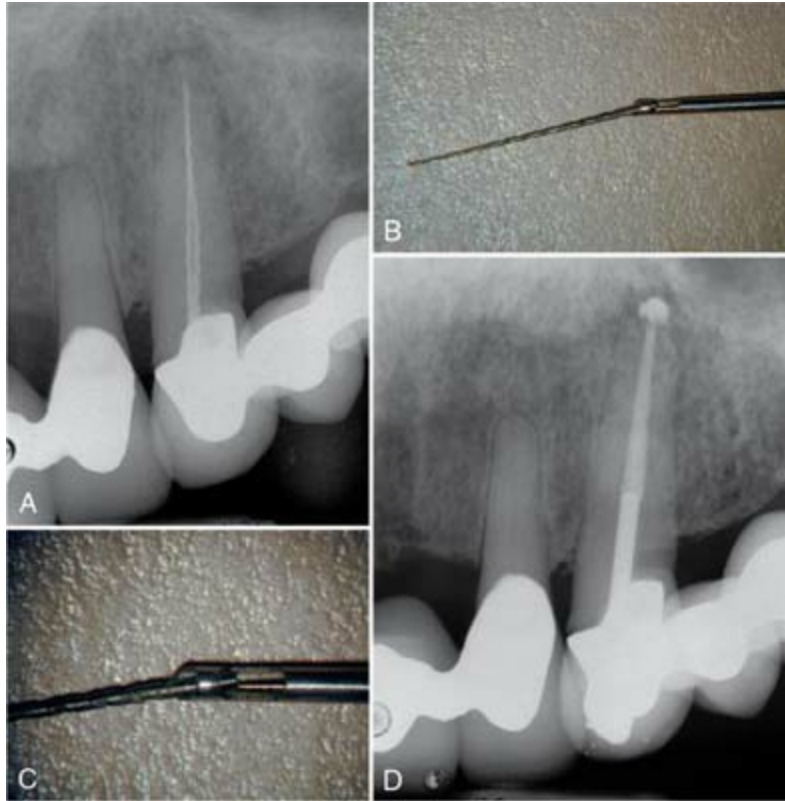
A, Preoperative radiograph showing two separated instruments in one tooth. B, IRS instrument with a removed file. C, Note that large size files are difficult to push through the cutout window. D, Postoperative radiograph.
